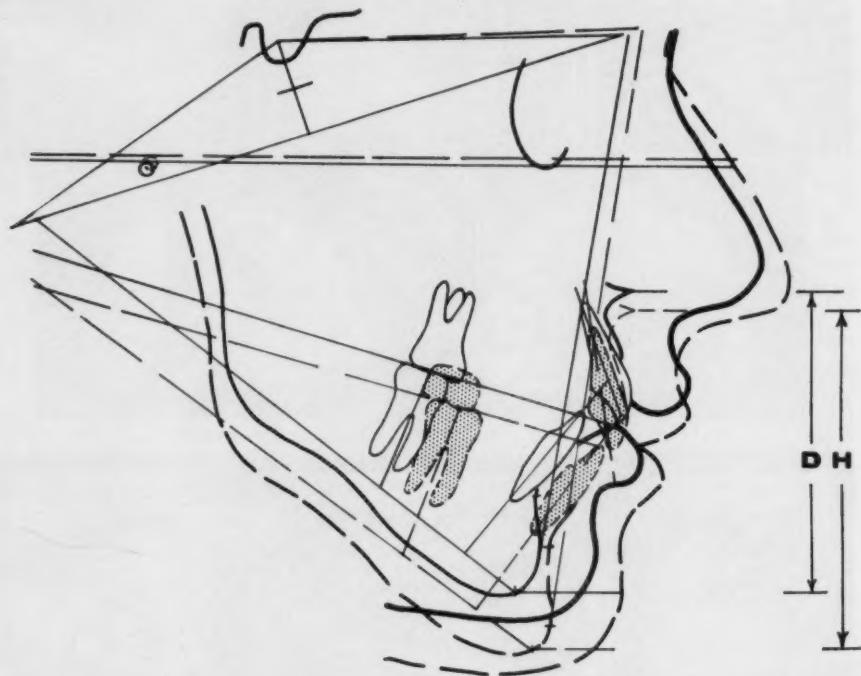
Case 2, Patient J. H. Superposed tracings of cephalometric roentgenograms. Solid line, December, 1951; broken line, February, 1955.
